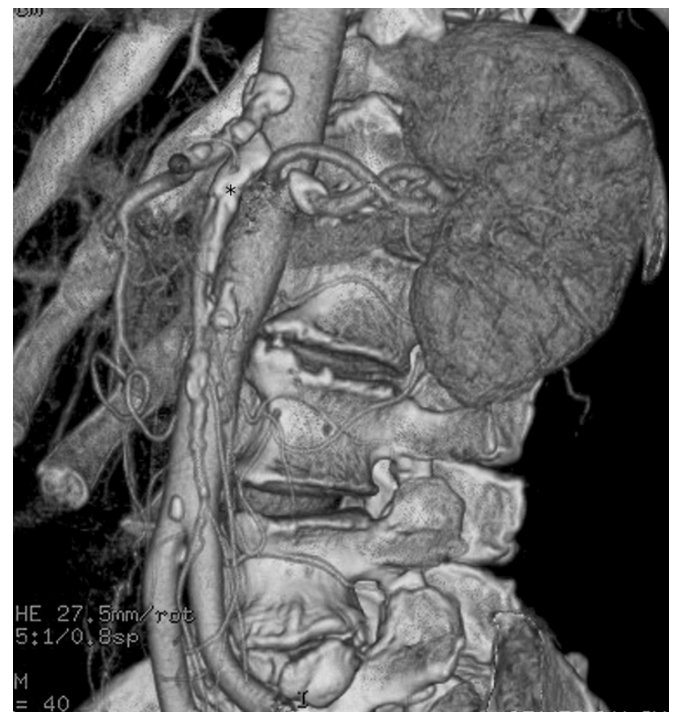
Preoperative computed tomography angiography scan revealed occlusion of the superior mesenteric artery origin with intimal calcified plaque (*) at proximal segment.
